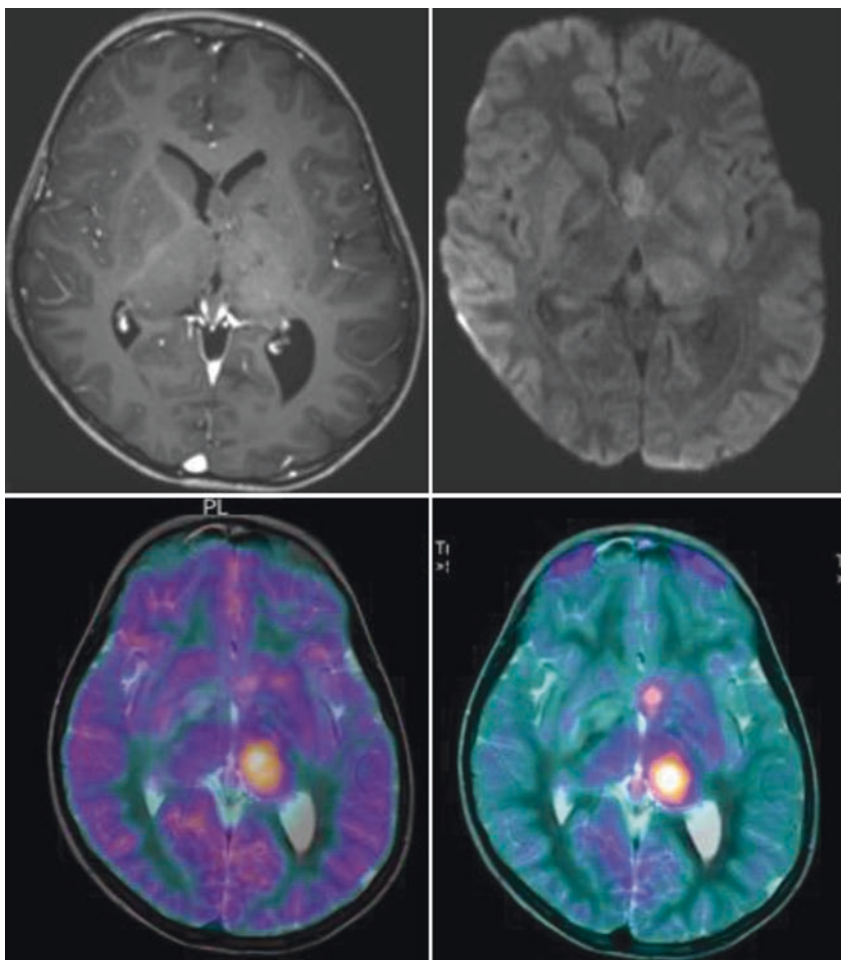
Nonenhancing left thalamic tumour showing mild restricted diffusion (top right). FDG PET (bottom left) shows intense metabolic activity in the left thalamus but ^{11}C -MET PET (bottom right) clearly demonstrates the presence of viable tissue also in the anterior commissure
